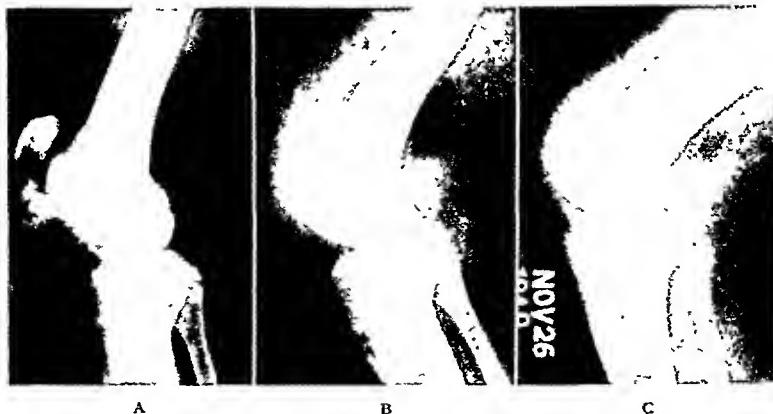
Case V. Regeneration of the patella? (Eighteen months.) A, preoperative x-ray of right knee. B, same knee one month postoperatively. Note early evidence of patellar regeneration. C, same knee, eighteen months postoperatively. Note progressive regeneration. Patellar mass can be palpated.
